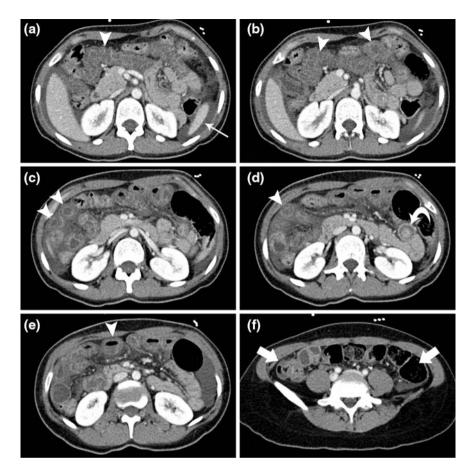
Contrast-enhanced CT images obtained during the abdominal attack, showing peritoneal fluid (a *thin arrow*) and thickening and oedema of the ileum wall (a–*e arrowheads*). The jejunum was normal (c, d *arrows*). At the jejuno-ileal junction, a target-like image corresponding to an intussusception was visible (d *curve arrow*). The colon was normal (f *large arrow*)
